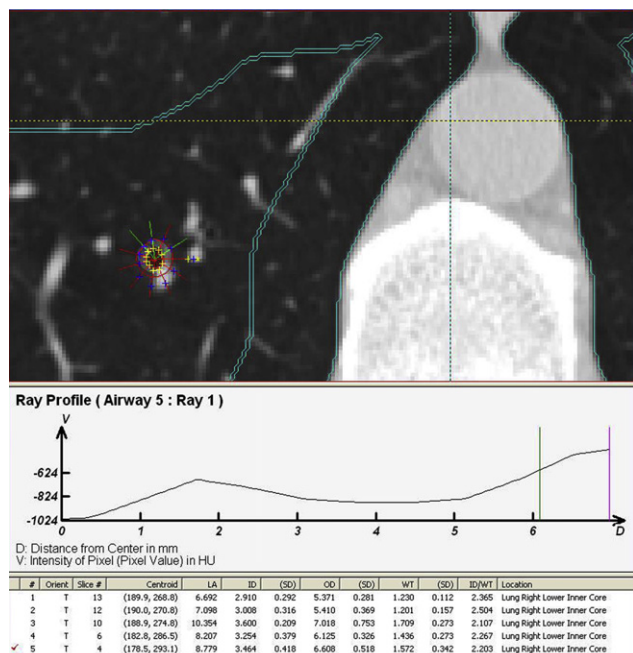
Airway measurements on CT scan. Upon locating an airway perpendicular to the plane, a centroid was placed in the center of the airway, from which the Pulmonary Analysis Software Suite generated rays and inner and outer airway diameters. If a ray extended into adjacent tissue the analyst would manually exclude it and the PASS system would regenerate the inner and outer diameter to better conform to the shape of the airway. The remaining rays were averaged to calculate airway wall thickness and lumen diameter.
